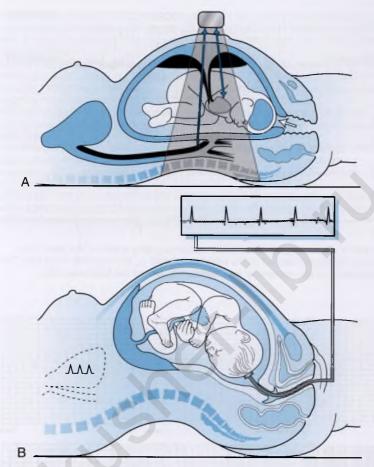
Recording fetal heart rate by (A) ultrasound transducer; (B) scalp electrode.
